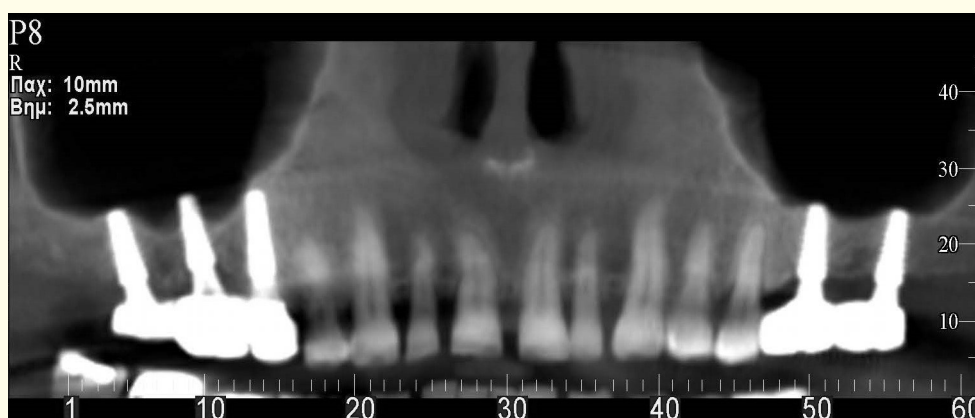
Panoramic view of final CBCT.
